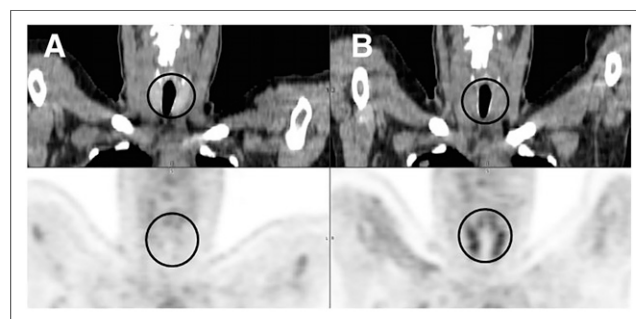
Patient with increased ^{18}F -FDG uptake in thyroid gland during nivolumab therapy. (A) Coronal CT (top) and ^{18}F -FDG PET (left) images before therapy show normal uptake in thyroid gland, with SUV_{max} of 1.7. (B) Coronal CT (top) and ^{18}F -FDG PET (bottom) images during therapy show increased thyroid uptake, with SUV_{max} of 4.3. Region of thyroid gland is encircled.
